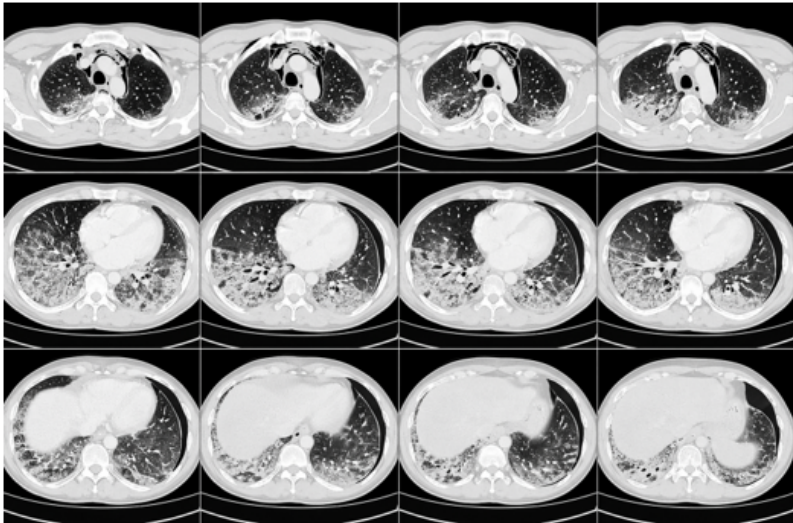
Follow-up chest CT (day 3): Lower-lobe parenchymal consolidations, ground-glass opacities and septal lines forming a “crazy-paving” pattern - established aspiration pneumonia.
